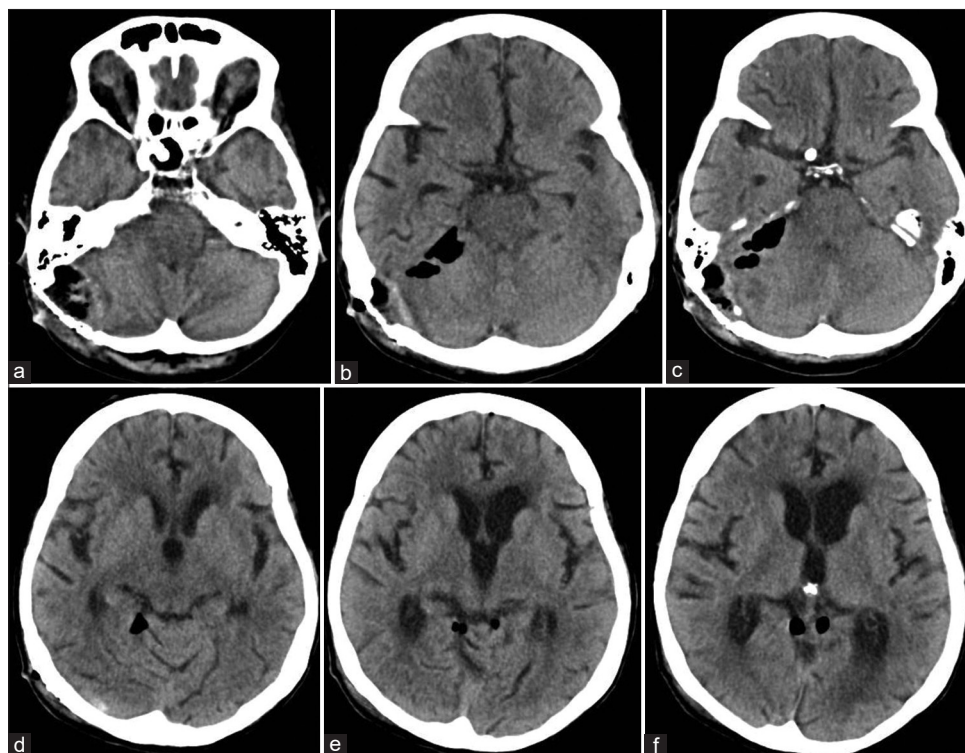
Postoperative day 2 CT scan of the head without contrast material. (a-f) Respectively, caudal to rostral serial images demonstrating mostly resolved pneumocephalus.
